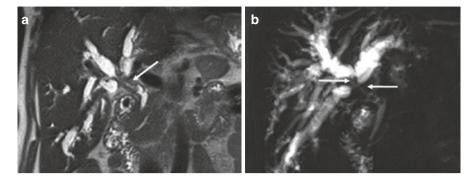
Magnetic resonance imaging of hilar cholangiocarcinoma: (a) coronal T2-weighted image of irregular ductal wall thickening (arrow) at the confluence; (b) two-dimensional magnetic resonance cholangiography image of a hilar mass (arrows) (with permission, adapted from [176])
